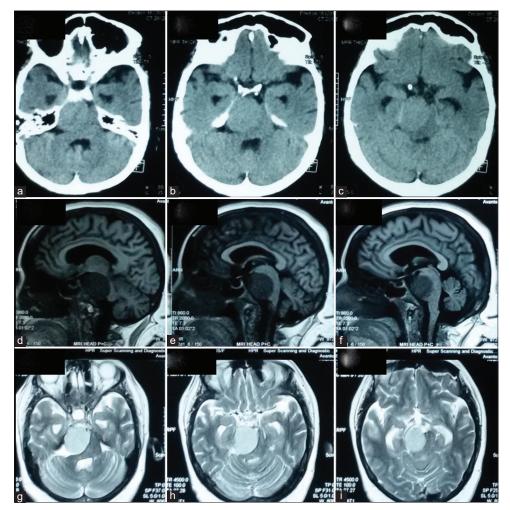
(a-c) Axial noncontrast computed tomography head showing isointense tumor in the right incisural space causing distortion of the brain stem and producing mass effect. (d-f) Magnetic resonance imaging (MRI) T1WI sagittal section showing hypodense tumor anterolateral to the brain stem and posterior to clivus. (g-i) MRI T2WI axial section showing hyperintense tumor in the right incisural space causing distortion of the brain stem and producing mass effect.
